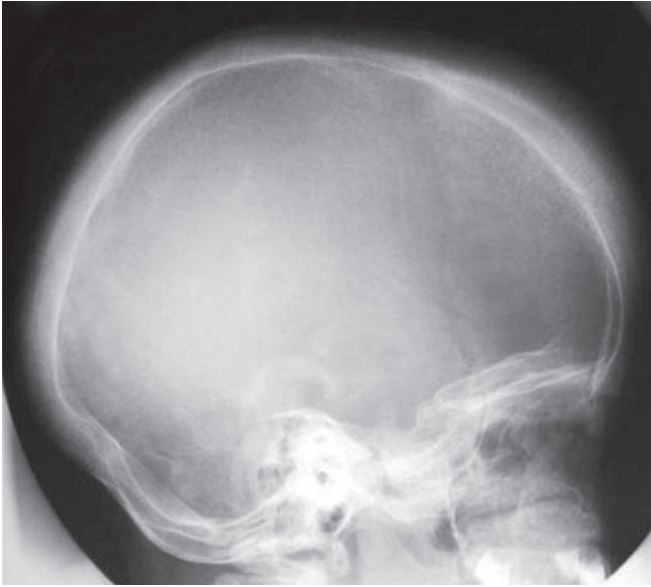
Thalassaemia. There is widening of the diploic space and thinning of the outer table of the skull. Note the hair-on-end appearance in the frontal region on this lateral skull radiograph
